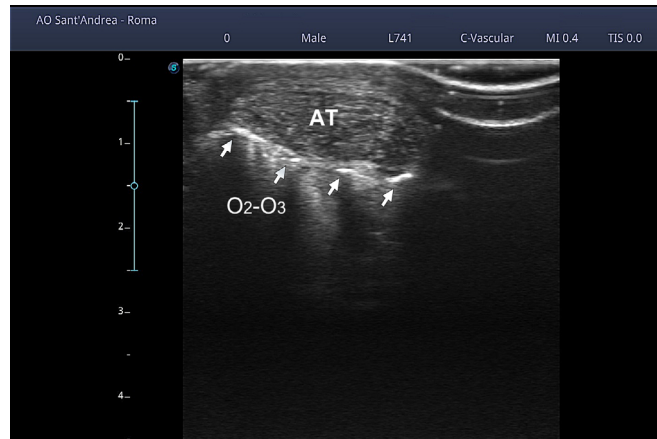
Achilles tendon ultrasound-guided infiltration.
